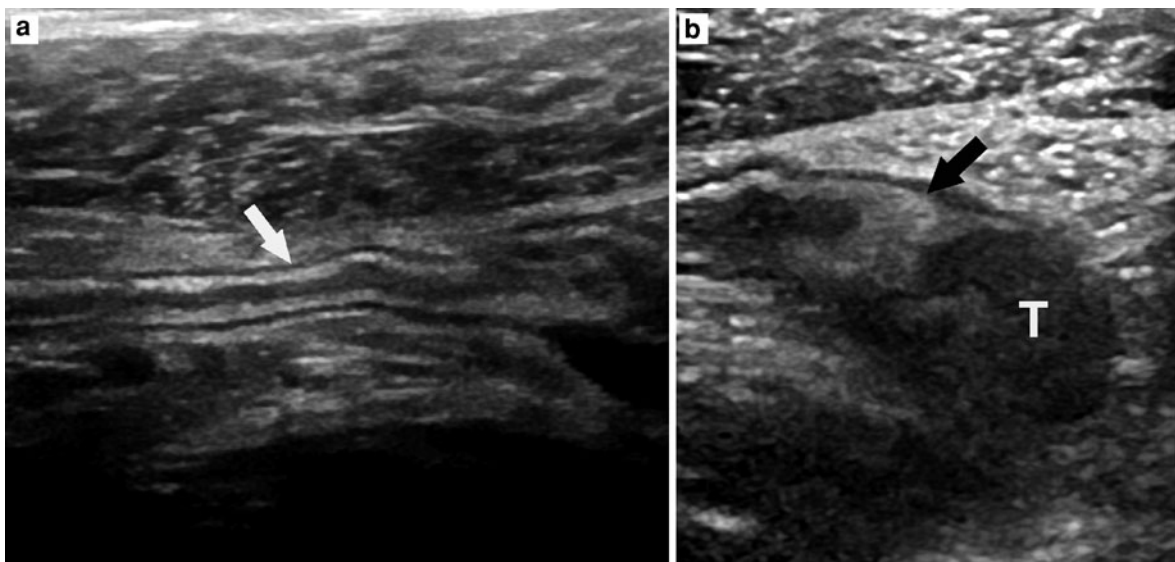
a, b Tip appendicitis. a is long-axis grayscale sonogram demonstrating normal proximal appendix (*arrow*). b is long-axis grayscale sonogram through distal tip, demonstrating marked
